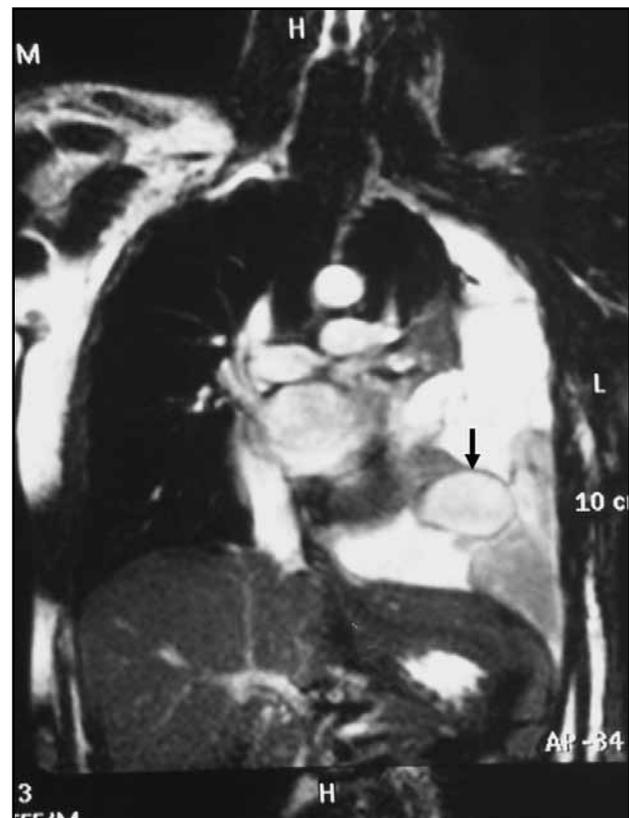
A thoracic magnetic resonance image (coronal view) demonstrating the collapsed left lung as a result of haemothorax in a pregnant woman. Note the well-circumscribed high-signal lesion corresponding to the pulmonary arteriovenous malformation located in the left lower lobe (arrow)
